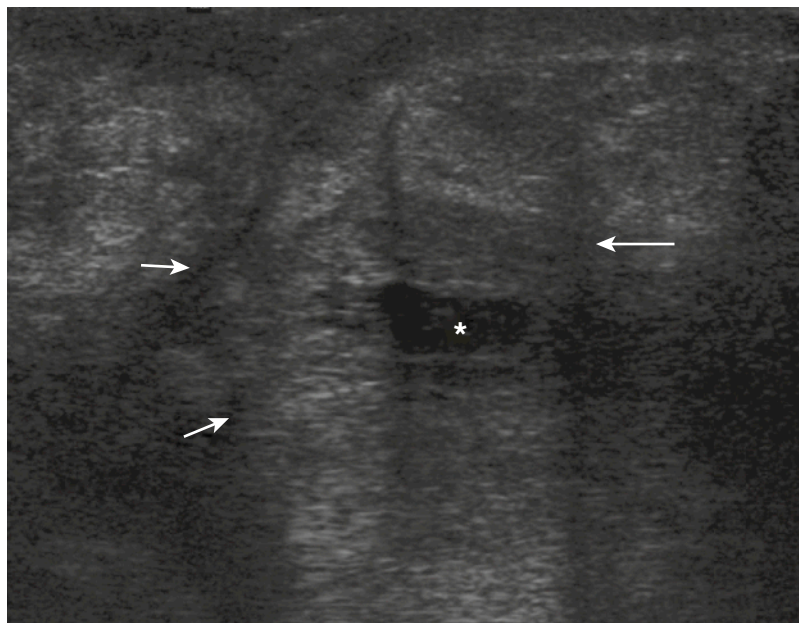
Longitudinal sonogram shows a thick-walled abscess, with a *large arrow* pointing at the lesion, *small arrows* indicating marginal edema, and a *star* marking central fluid or necrosis.
